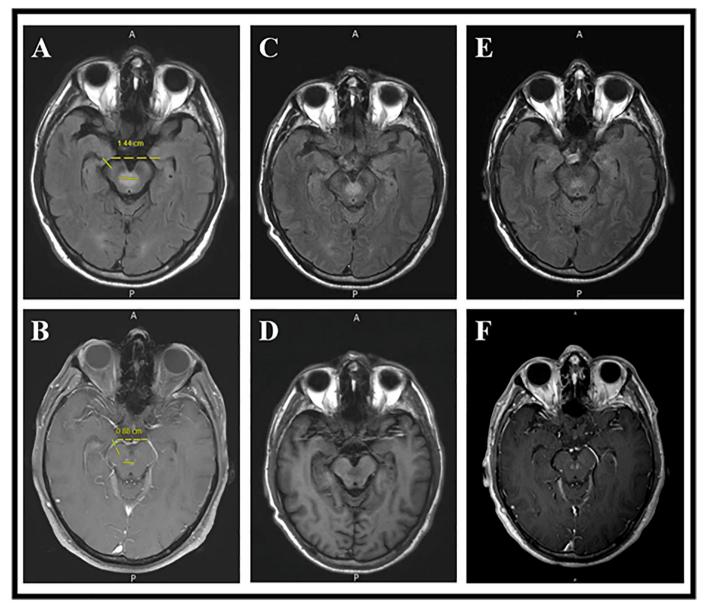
T1 and T2-weighted MRI of the case over time.
